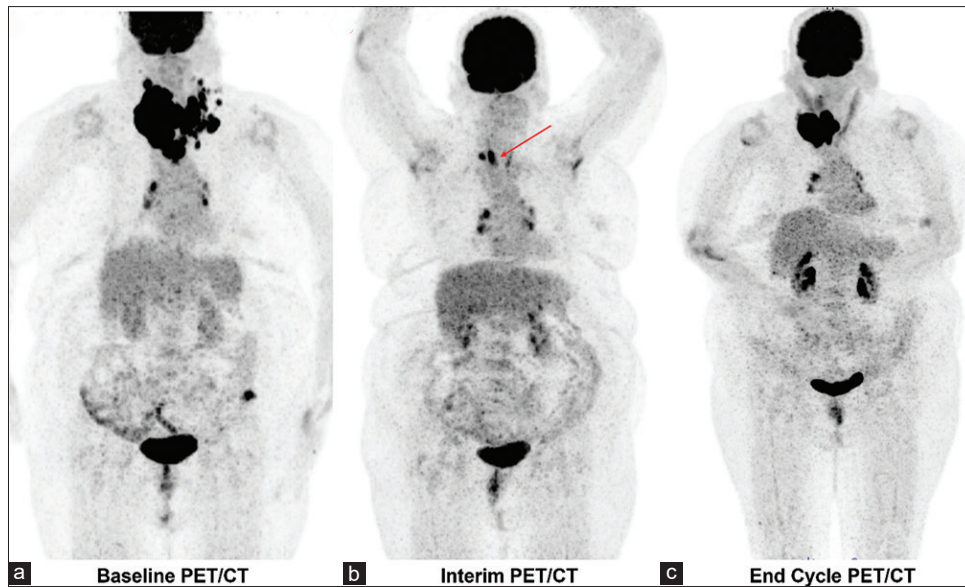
Baseline FDG PET/CT MIP image (a) revealed increased tracer uptake in enlarged thyroid mass with multiple cervical and mediastinal lymphadenopathy, interim FDG PET/CT MIP image (b) after chemotherapy revealed a significant decrease in thyroid mass with decreased uptake suggestive of partial response to chemotherapy. End cycle FDG PET/CT (c) revealed a further increase in thyroid mass with increased uptake suggestive of Disease recurrence
